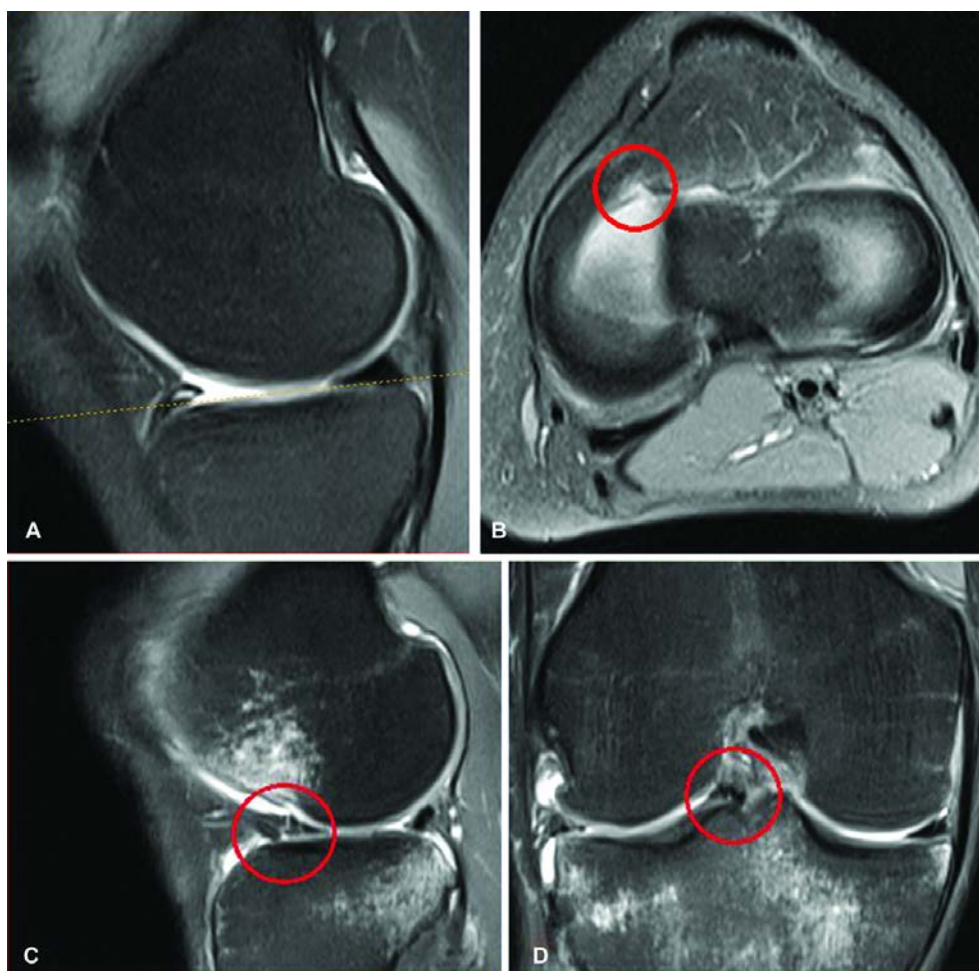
MRI scans of the left and right knees in a 2-year-old patient T. showing: A – sagittal view demonstrating longitudinal linear portion in the anterior horn of the medial meniscus (left knee) Stoller grade III; B – transverse image demonstrating architectonics of the anterior horn root tear of the medial meniscus; C – sagittal view demonstrating vertical linear portion in the anterior horn of the lateral meniscus (right knee) Stoller grade III; D – transverse view showing displaced lateral meniscus (bucket handle tear) in intercondylar tubercle
